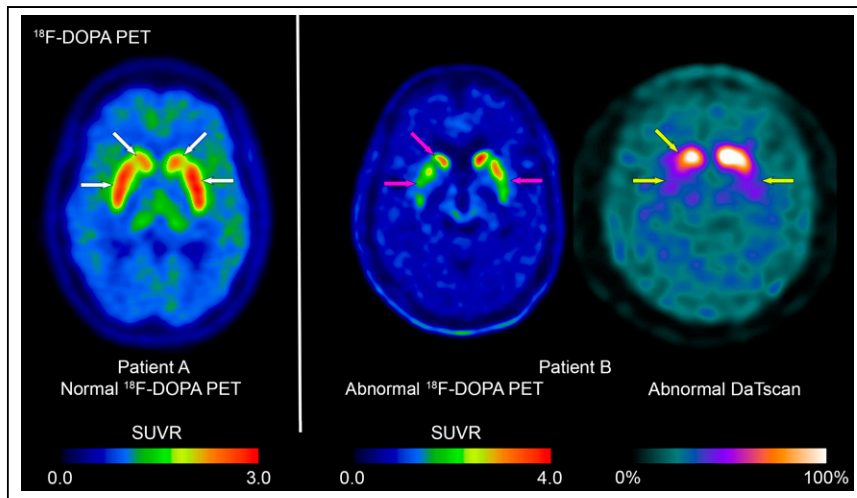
Dopaminergic PET. (Left) Normal ^{18}F -DOPA PET examination with expected uptake in caudate and putamen bilaterally (arrows). (Center) Abnormal ^{18}F -DOPA PET examination in 43-y-old woman with onset of Parkinson disease at early age. Abnormal examination shows diminished uptake in bilateral putamina, asymmetrically worse on patient's right, and subtle decreased uptake in patient's right caudate (arrows). (Right) In same patient, ^{123}I -ioflupane SPECT (DaTscan; GE Healthcare) was also abnormal, with decreased basal ganglia uptake (arrows) causing loss of expected comma-shaped region of uptake, asymmetrically worse on patient's right. SUVR = SUV ratio.
